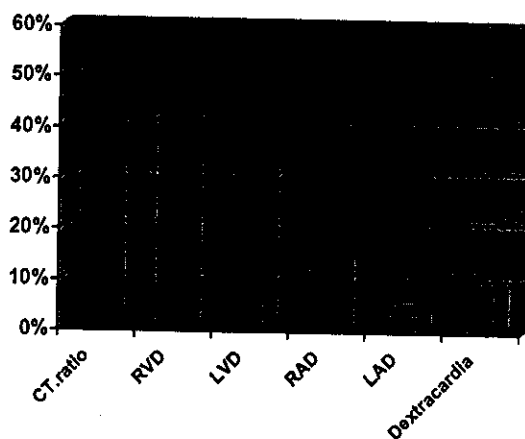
Showing the X-ray finding in all patients.
